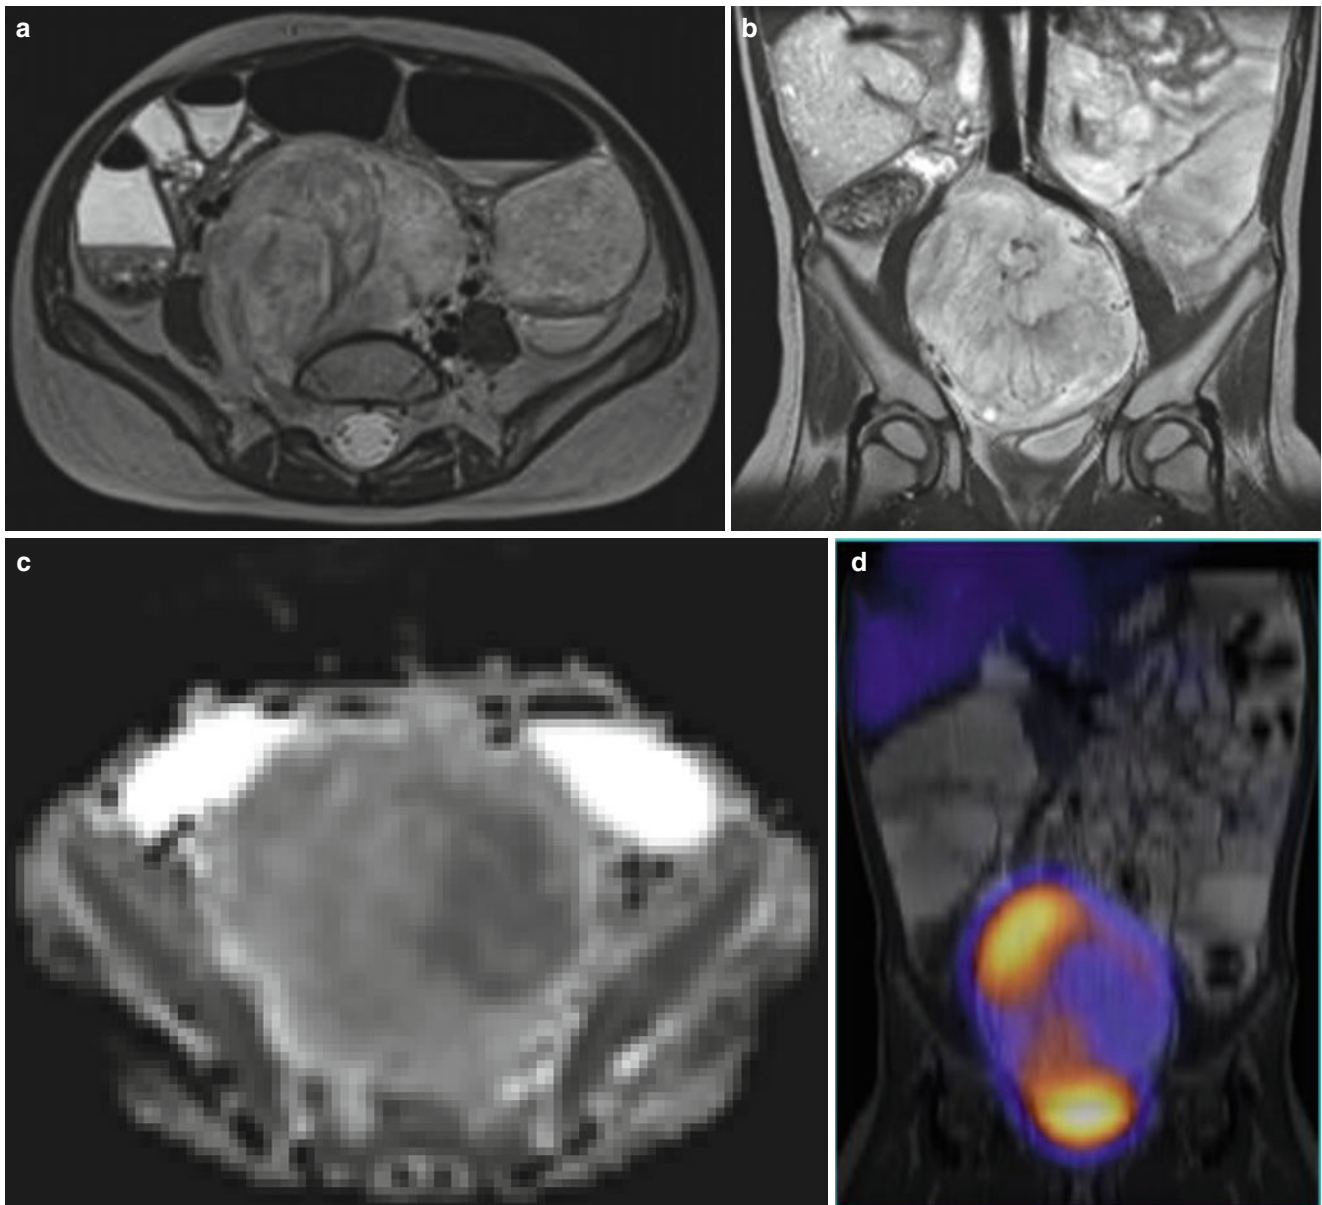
Ganglioneuroblastoma. A large pelvic tumor on axial (a) and coronal (b) MRI is heterogeneous, enhances and extends into the L5 neural foramen (a). The ADC map was very heterogeneous (c), and thus although an initial biopsy of the centre of the mass revealed ganglioneuroma (benign), there was concern that the tumor did not respond to chemotherapy. MIBG showed high uptake in the periphery of the mass
